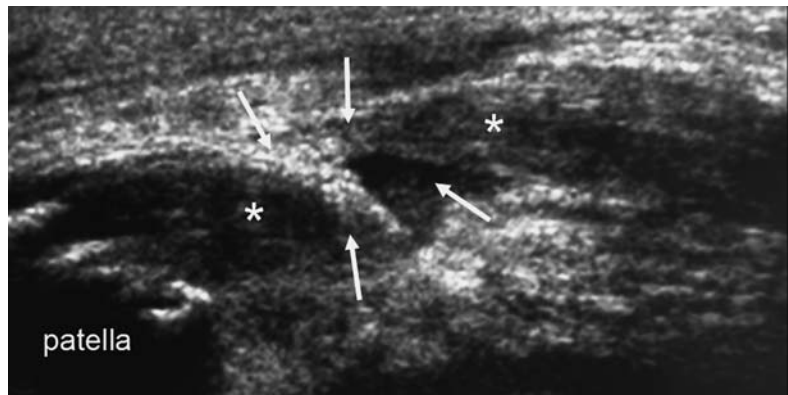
Patellar rupture. Sagittal ultrasound shows a defect in the proximal portion of the tendon (*arrows*). The asterisk marks the free ends of the tendon
